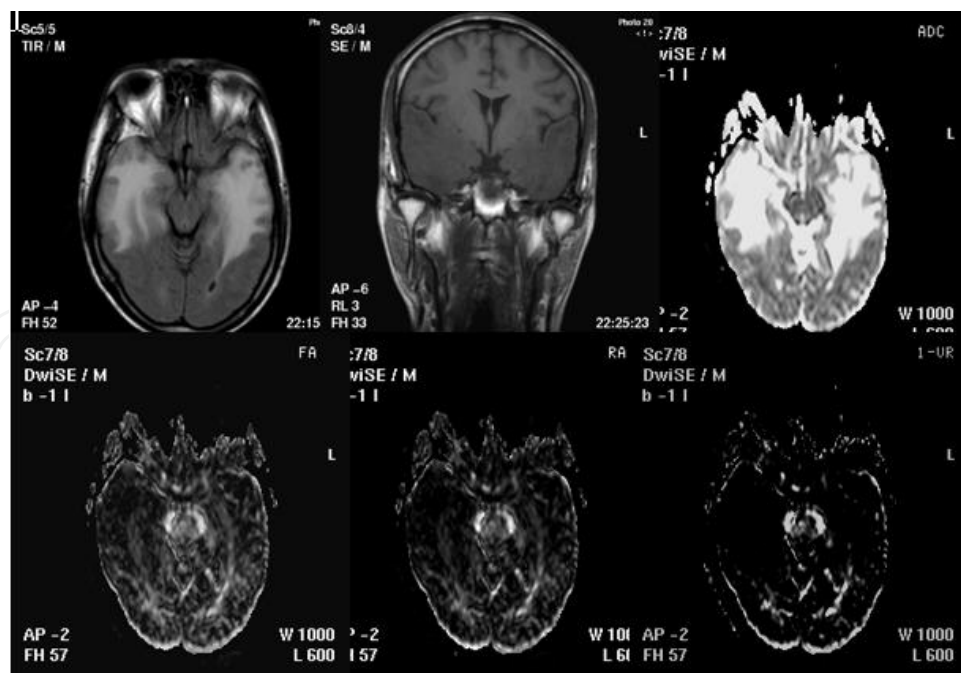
Delayed RIBI of bilateral temporal. Edema is obvious. Isotropic map shows high signal in the lesion area which is wider than FLAIR. Anisotropic map shows low signal in the bilateral temporal lobe and white matter fiber of the normal temporal lobe shows high signal and blurred.
